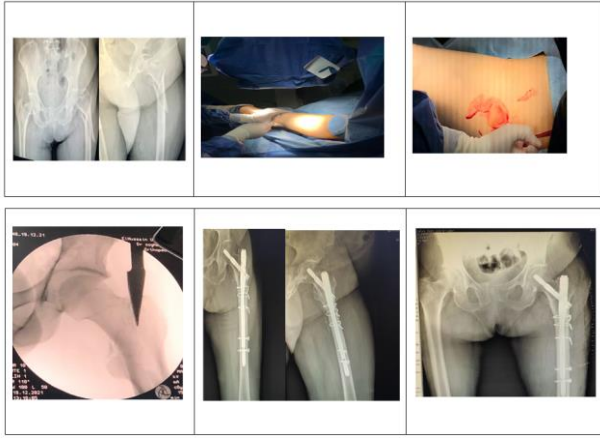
Shows case 1 Postoperative X-rays 2
